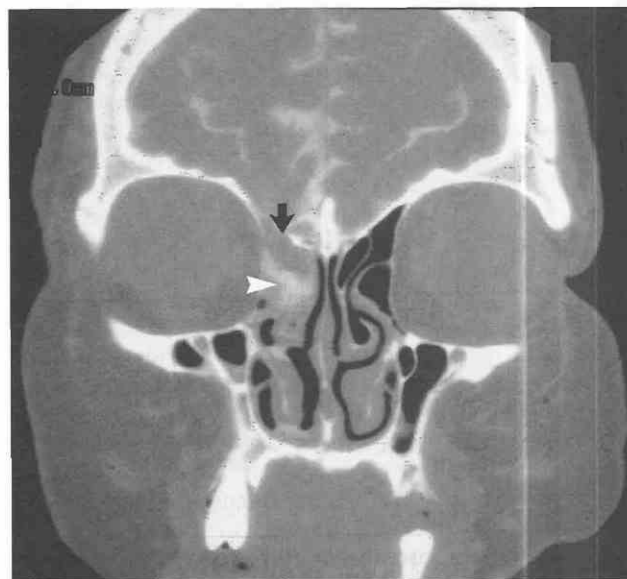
Post-traumatic cerebrospinal fluid leak. High-resolution direct coronal CT cisternogram demonstrates leakage of contrast material in the right ethmoid sinus (arrowhead) and the fracture site in the right cribriform plate (arrow).
